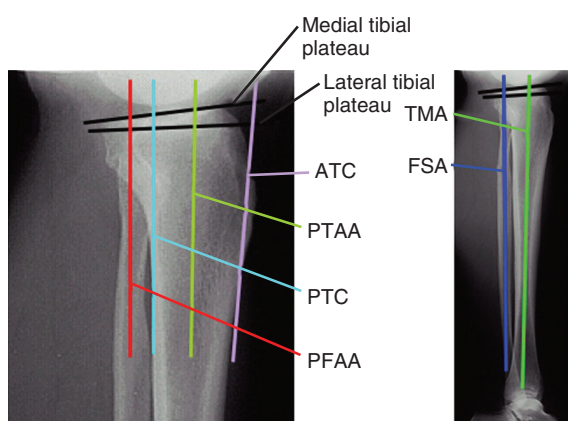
Some reported radiographic techniques to measure the tibial slope. The values obtained depend on the anatomic site selected on the tibia. Selected literature references for reported values are shown in Table 26-3. ATC, Anterior tibial cortex; FSA, fibular shaft axis; PFAA, proximal fibular anatomic axis; PTAA, proximal tibial anatomic axis; PTC, posterior tibial cortex; TMA, tibial mechanical axis. (From Noyes FR, Goebel SX, West J. Opening wedge tibial osteotomy: the 3-triangle method to correct axial alignment and tibial slope. *Am J Sports Med.* 2005;33:378-387.)
